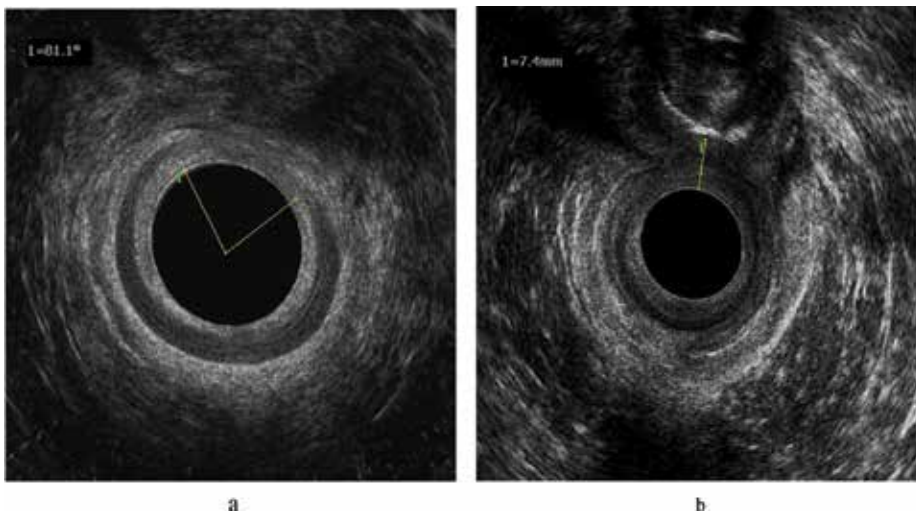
a. Endoanal ultrasound view of anterior anal sphincter defect; IAS defect seen as the discontinuity of the hypoechoic (dark) ring and EAS defect seen as the discontinuity of the hyperechoic (white) ring. b. Perineal body measurement; the hyperechoic shadow is the examiner's index finger that presses against the patient's posterior vaginal wall.
